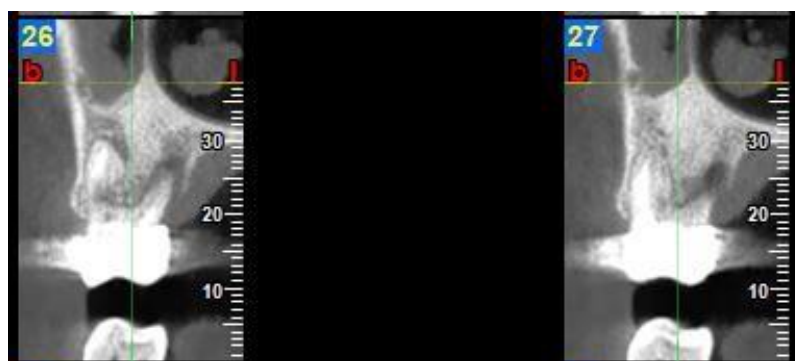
CBCT confirmed the presence of periapical odontogenic lesions organized on the two mesial and disto-vestibular roots.
